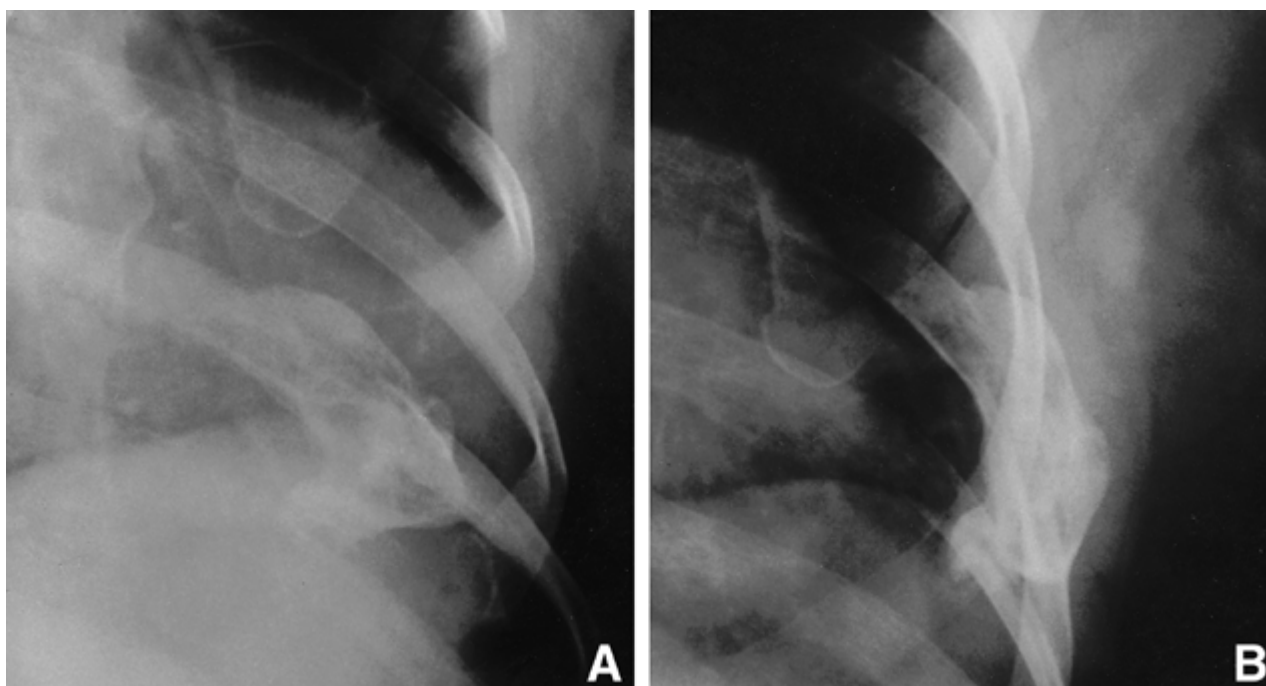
The antero-posterior (A) and oblique (B) radiographs show a sharply defined lobulated bony mass measuring 6×3 cm in size. Marginal irregularity is noted at the lower border of the lesion.
